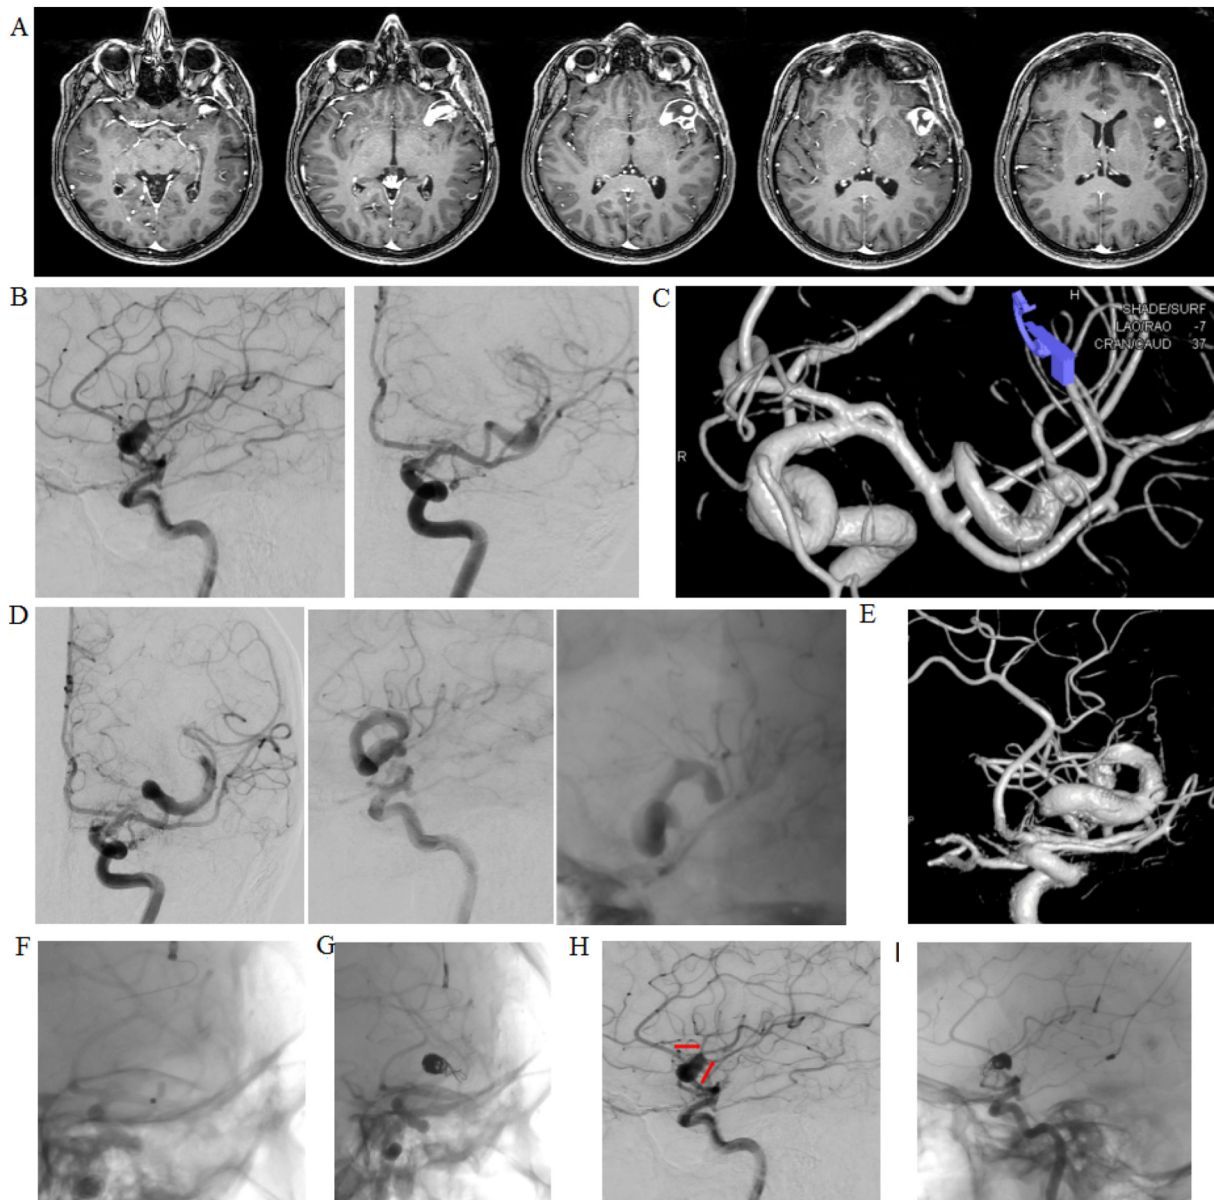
(a) T1-weighted MRI axial slices. (b) First angiography showing the fusiform aneurysm in the insular branch of the left middle cerebral artery. (c) 3D reconstruction of the fusiform aneurysm showing two emerging vessels. (d) One-year follow-up angiography. The aneurysm is significantly longer. (e) 3D reconstruction shows that the perfusion is clearly slower. (f) A balloon is positioned in the aneurysmal branch of the MCA. Neuropsychological tests were performed during occlusion lasting 25 min. (g) Endovascular occlusion of the branch and exclusion of the fusiform aneurysm. (h) Pre-occlusion. (i) Post-occlusion. Red arrows indicate the two vessels emerging from the aneurysm. (For interpretation of the references to colour in this figure legend, the reader is referred to the web version of this article.)
